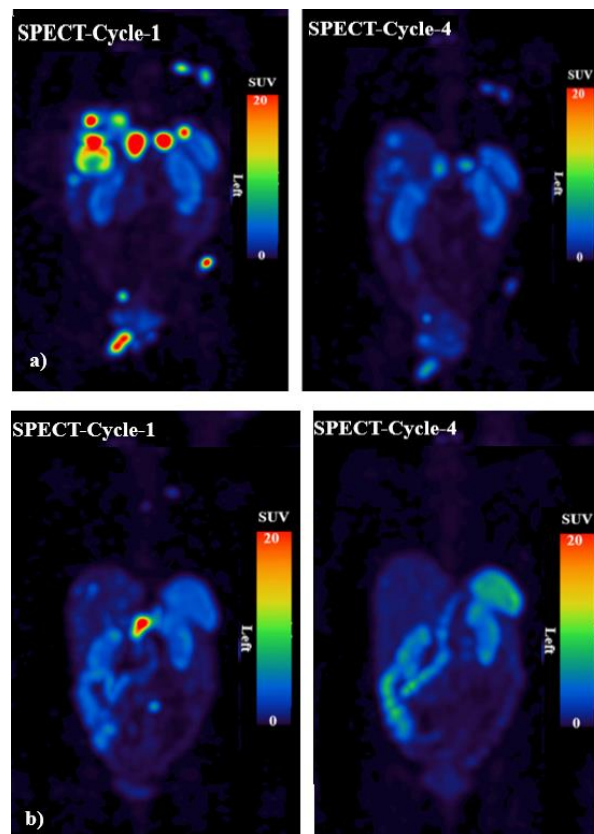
Examples of two PRRT patients' SPECT/CT MIP images. a) Patient DOTA-7 showed a reduction in restrictions following cycle 4 PRRT by 4 days, and b) patient DOTA-5 showed a reduction by 8 days.
